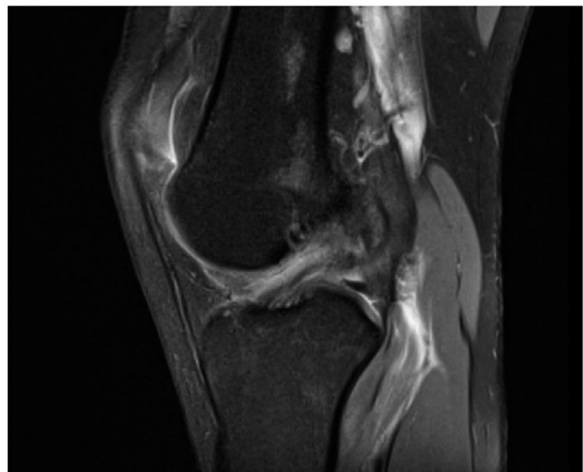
MRI scan knee sagittal T2 view
